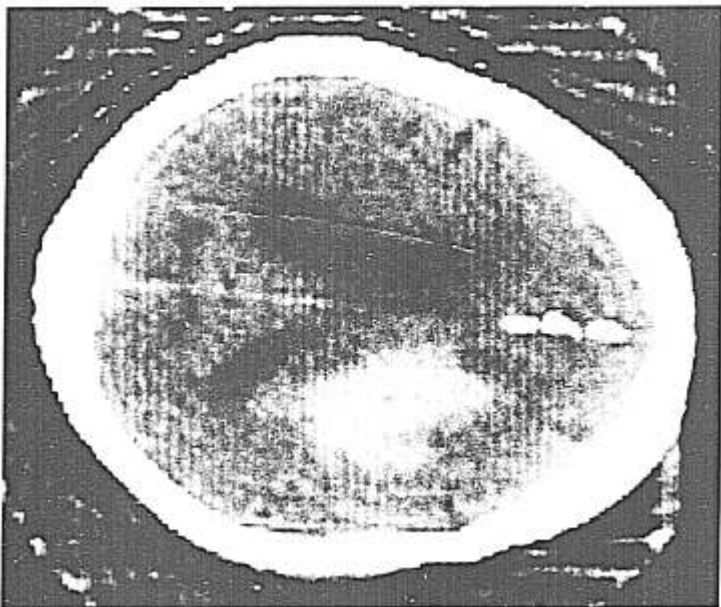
CT shows elongated, irregular white density in the right hemisphere consistent with an intracerebral hematoma. It compresses the body of the right lateral ventricle. Decreased density in its periphery represents edema. Hydrocephalus is present, as evidenced by enlarged left lateral ventricle.
